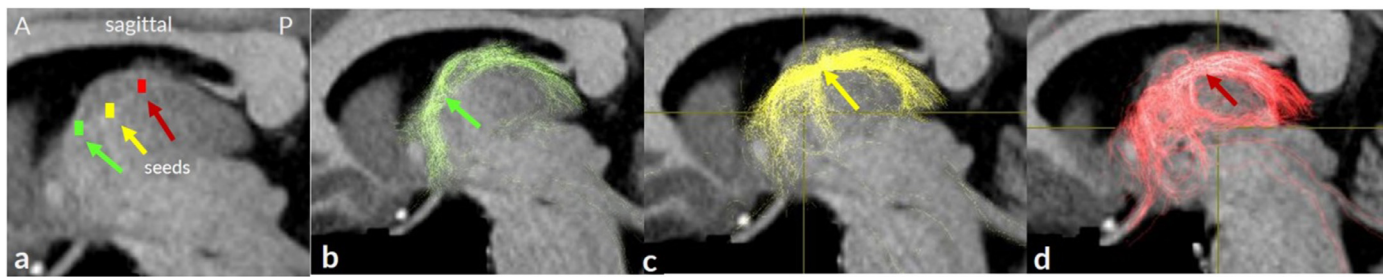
Tractograms of subareas of the ANT region (colored squares) derived from diffusion MRI of a HCP subject overlaid on a T1 image. The first sagittal image (a) shows the three different seed volumes used. The images b-d show that seed positions in different subareas of the ANT (left row) result in unequal trajectories and demonstrate the feasibility of distinguishing segregated pathways emanating from subnuclei of the ANT.
